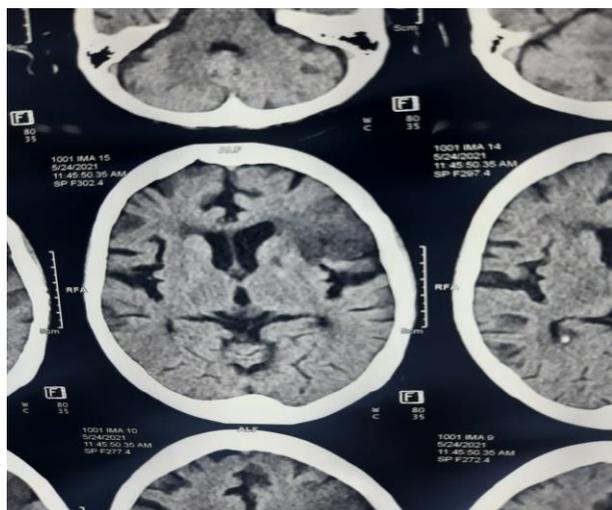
Plain CT brain showing left fronto-parietal infarct.
